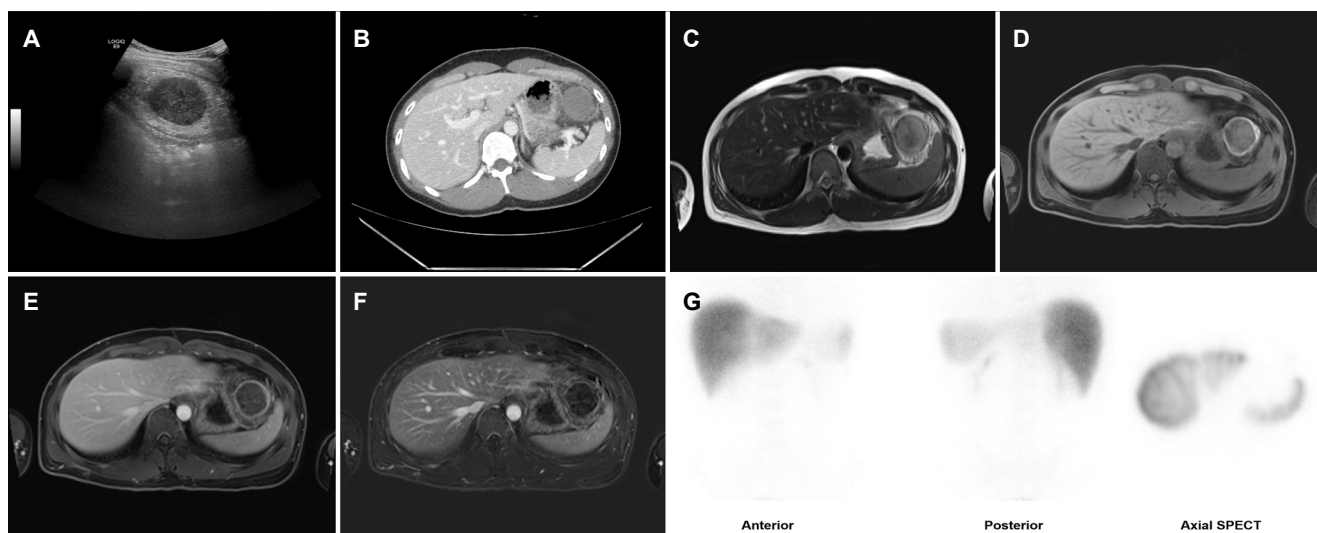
(A) Ultrasound image of the accessory spleen shows a hypoechoic mass with a well-defined margin. (B) Contrast-enhanced axial computed tomography image shows a well-defined, hypo-enhancing mass, measuring approx. 4.5 cm, in the left upper quadrant of the abdomen. (C) On axial T2-weighted image, the mass appears as a solid lesion with moderate-to-high signal intensity. On contrast-enhanced MR image obtained in the (D) pre-contrast phase, (E) portal phase, and (F) subtraction image of portal phase, the tumor shows relatively high signal intensity in the pre-contrast image and no enhancement except for a subtle and thin peripheral enhancement, which is indicative of coagulative necrosis due to ischemia. (G) Technetium-99m phytate scintigraphy and single-photon emission computed tomography (SPECT) images do not show radiotracer uptake within the abdominal mass.
